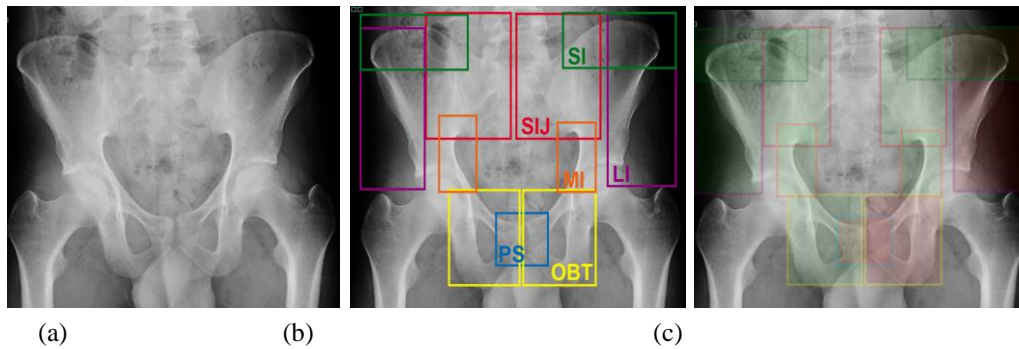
(a) Pelvic AP X-ray of a pelvic ring fracture; (b) Pelvic regions for radiological classification of traumatic pelvic ring fractures: PS, pubic symphysis (blue) and left and right OBT, obturator foramina (yellow), MI, medial ilium (orange), LI lateral ilium (purple), SI, superior ilium (green), and SIJ, sacroiliac joint (red); (b) Gestalt evaluation; (c) Per-region evaluation; (c) pelvic regions classification into normal (green) and fracture (red) regions.
